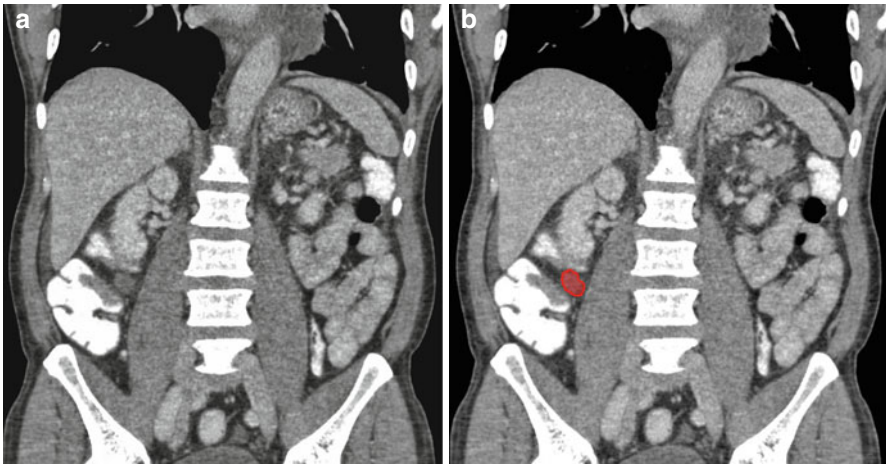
(a, b) Coronal reformatted CT image in a patient with cecal cancer shows prominent ileocolic lymph node (*red*)
